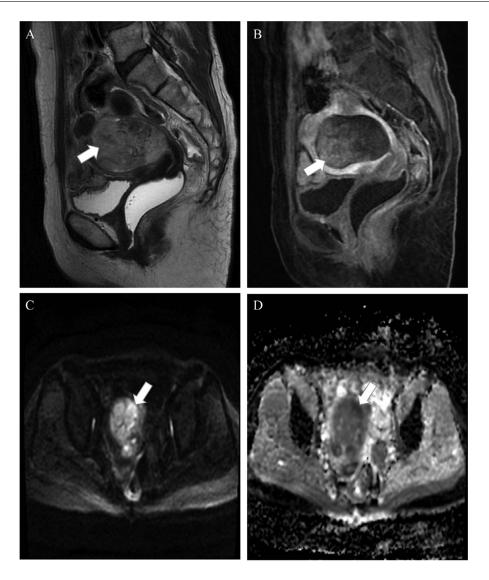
A heterogeneous mass (arrows) can be seen inside the uterus on the sagittal T2W (A). On T1W with contrast agent, the lesion showed weak enhancement (B). Within the mass, there are several regions with limited diffusion (arrow) on DWI (C) and matching low signal on the ADC map (D).
